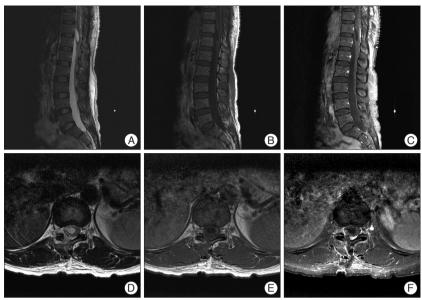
A postoperative magnetic resonance image reveals that the cystic lesion's size had decreased to 29×9.6 mm and that the spinal cord had decompressed.
